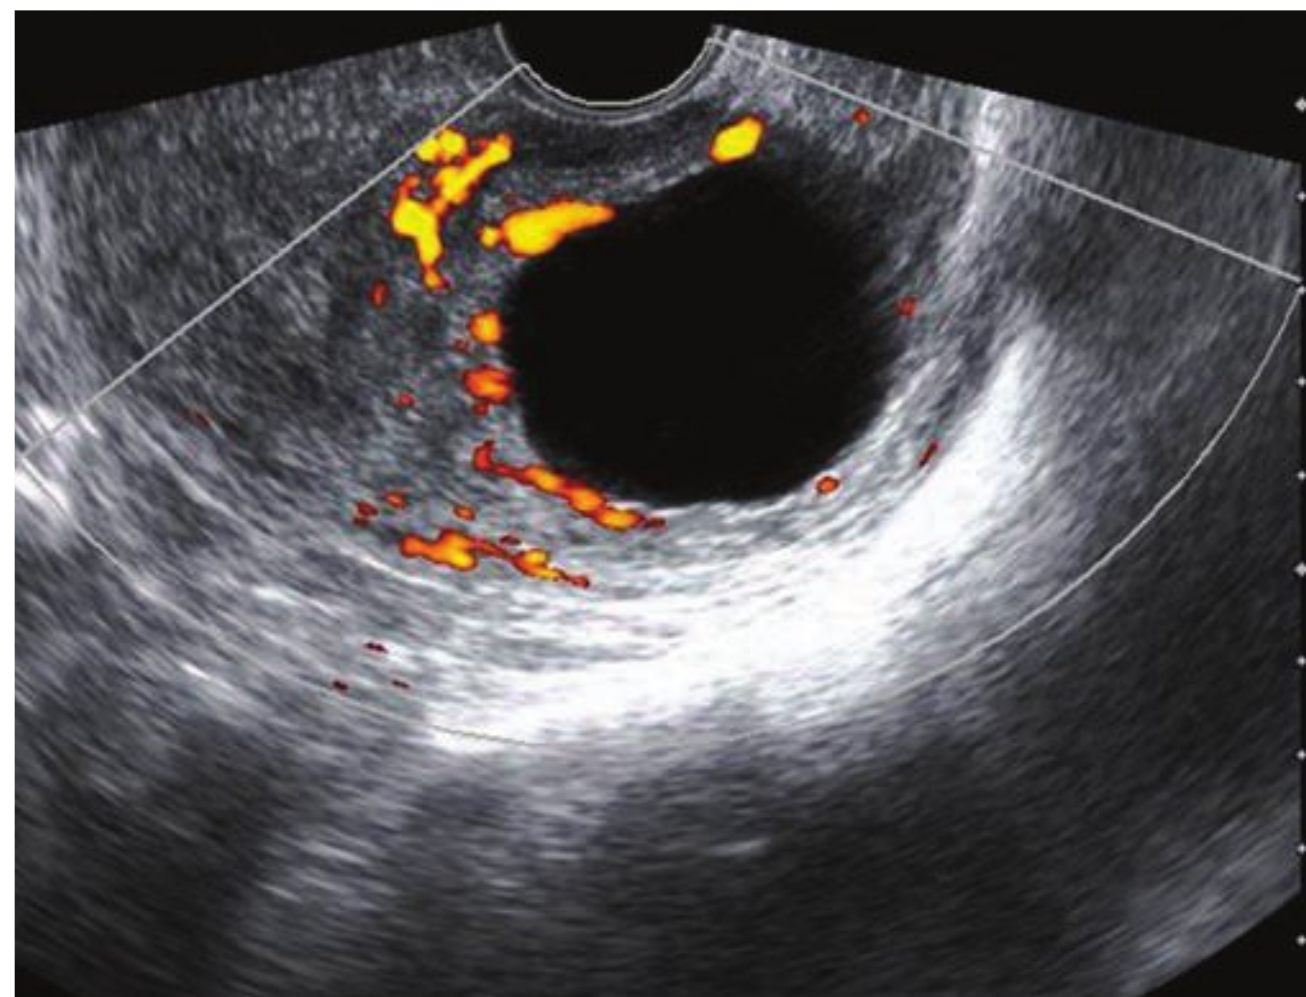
Power Doppler evaluation of a gestational sac in the lower uterine segment at the cesarean delivery scar. Circular flow is depicted, consistent with the peritrophoblastic flow of an implanted pregnancy.
